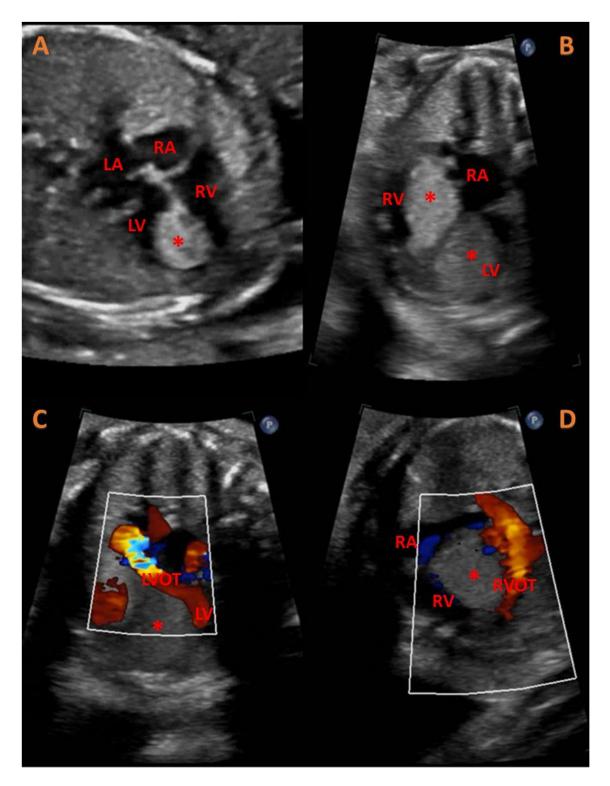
Fetal echocardiography of cardiac rhabdomyomas in this patient. A. Initial fetal echocardiogram demonstrating LV mass in a 4 chamber view, measuring 10 mm x 6 mm at
